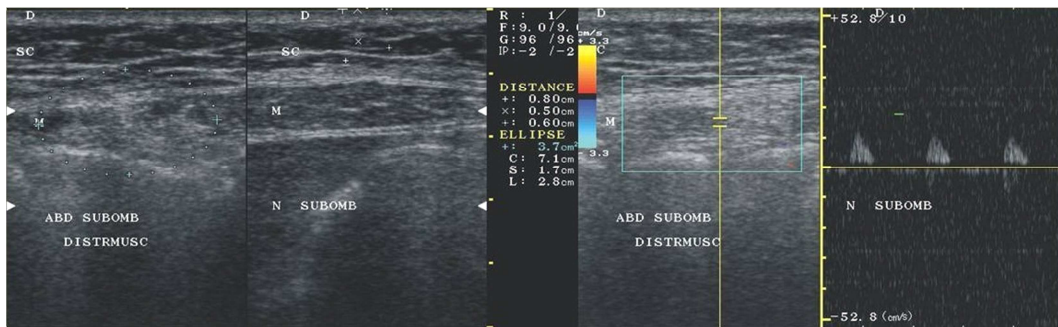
b: A Normalweight Child with Well Represented SC Layer Fat within Lower Abdominal Wall. An Initial Dystrophic Muscularis Area (Left) vs Normal (Right on the Split Screen Image). After 6 Months, the Same Dystrophic Area with Some Doppler Arterial Flow (Right).
